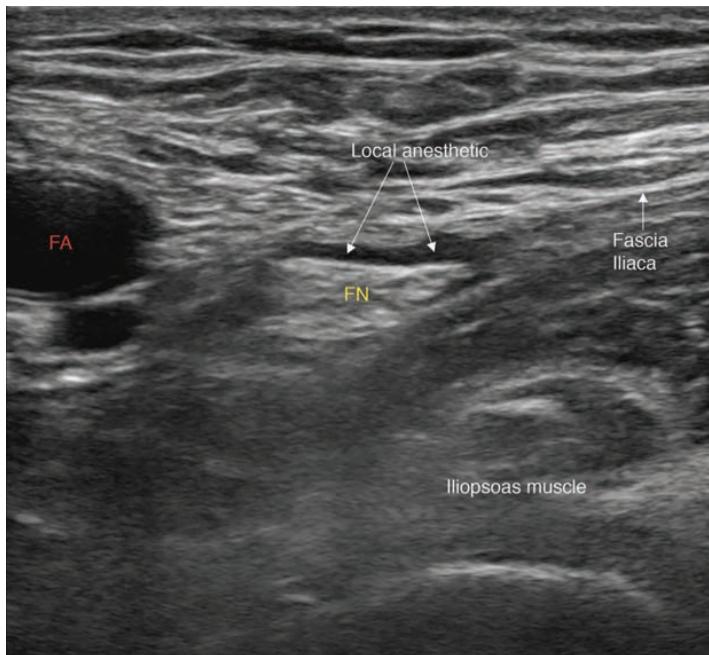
Ultrasound image after a femoral nerve (FN) block that shows an ideal spread of the local anesthetic. FA, femoral artery.
